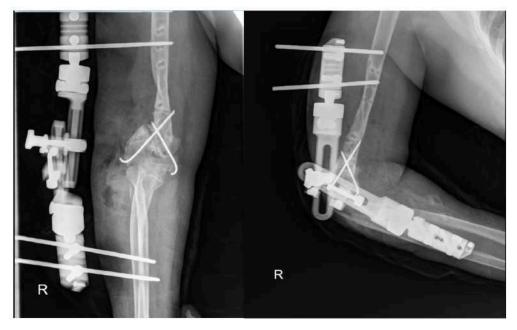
X-ray of humerus anteroposterior and lateral view after the surgery.
